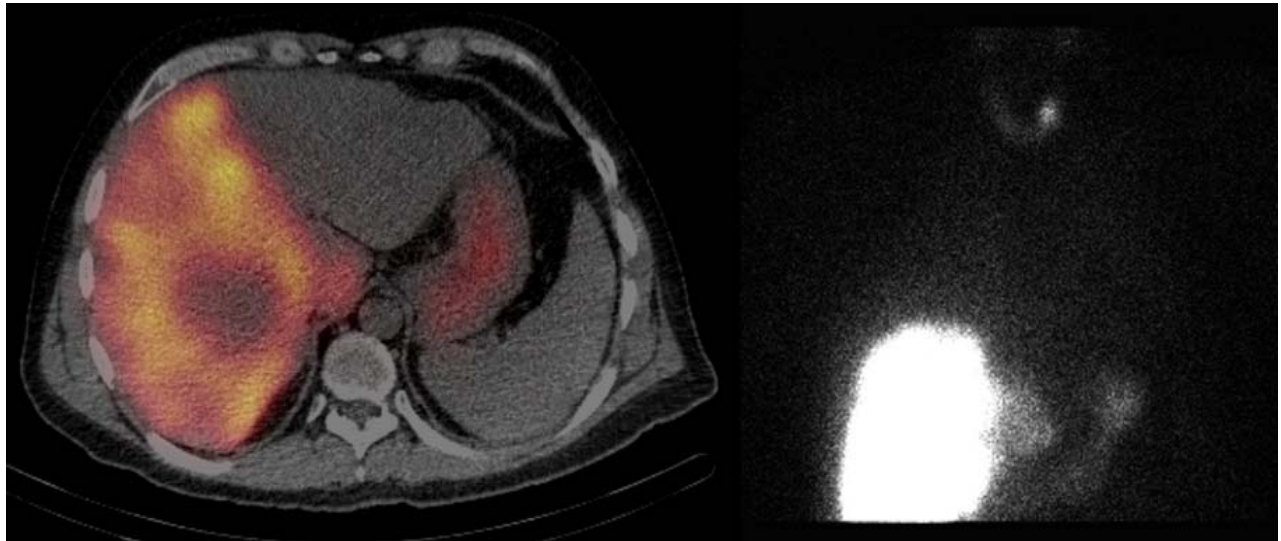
45 year-old male with metastatic adenocarcinoma of the gastro-esophageal junction with hepatic involvement was administered 155.4 MBq of ^{99m}Tc -MAA through a catheter placed in right hepatic artery; following administration, a SPECT/CT study was performed. The transaxial slice from the reconstructed SPECT/CT image of the abdomen reveals that both the right hepatic and caudate lobes were perfused with an inhomogeneous distribution of activity corresponding to the patient's multifocal intra-hepatic lesions. In addition, free ^{99m}Tc pertechnetate can be observed in the lumen of the stomach. Incidentally noted is a focal area of increased uptake in the region of the left upper pole of the thyroid gland.
